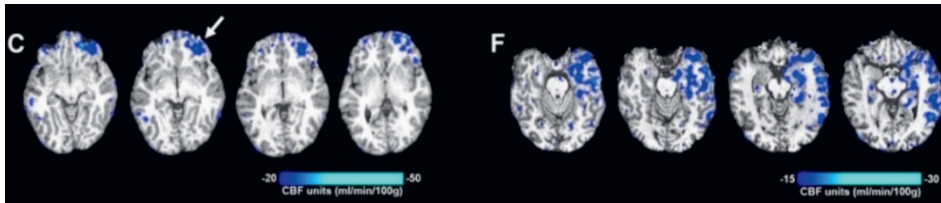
Subtraction cerebral blood flow (CBF) maps taken with ASL-MRI in a patient with frontal lobe epilepsy (C) and temporal lobe epilepsy (F). The four CBF maps show the transition from interictal to postictal state. Both patients show left hypoperfusion relative to seizure onset (left frontal with > 20 mL/100g/min, and left temporal with > 15 mL/100g/min, respectively). Figure taken from Farrell et al. 2016.
